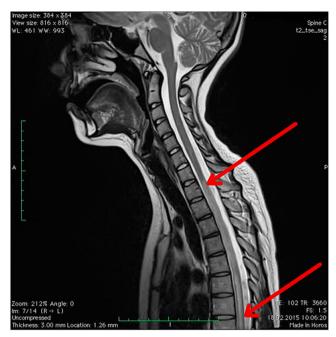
MR of the spinal cord of a female age 15, diagnosed with NMOSD: T2-weighted image, sagital view – the picture of longitudinally extensive transverse myelitis, extending from C6 to Th11 level
